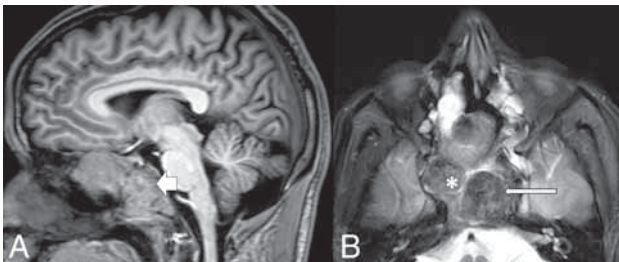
MR imaging features of GCG. A, Heterogeneous intermediate-to-high signal intensity (*short arrow*) on the T1-weighted sagittal image. B, Mixed intermediate-to-hyperintense (*white asterisk*) and hypointense (*long arrow*) solid components on T2-weighted axial image in the sphenoid bone and clival GCG.
